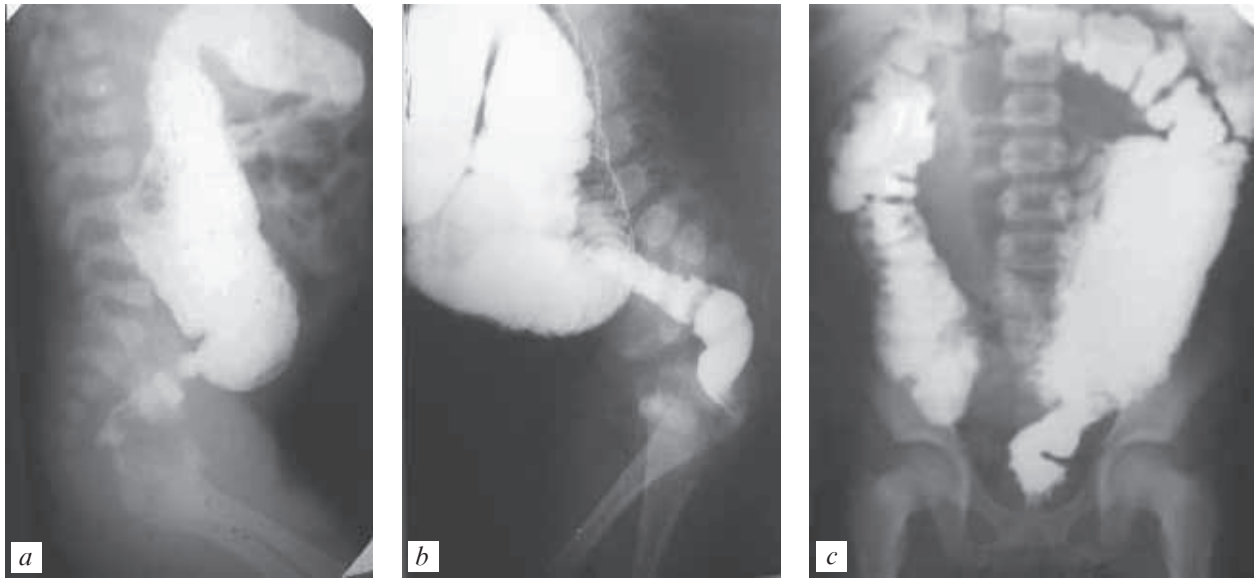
X-ray picture of Hirschsprung's disease (irrigograms) (a-c)
